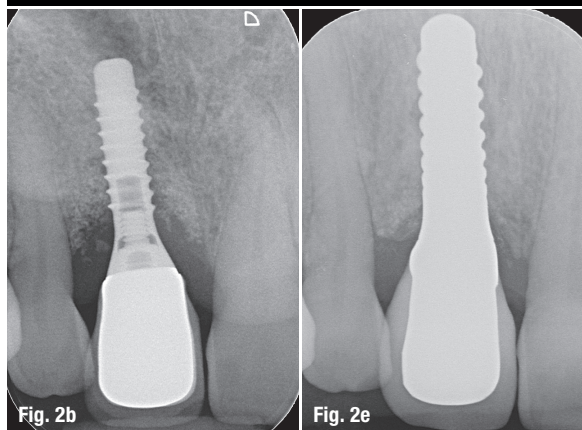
Initial clinical situation after non-surgical peri-implantitis pretreatment. Fig. 2b: Radiograph showing evident peri-implant bone loss. Fig. 2c: Clinical situation at implant placement (PURE Ceramic Implant Monotype, Straumann) four months after implant removal and subsequent augmentation with autogenous bone. Fig. 2d: Clinical situation four weeks after cementation of definitive crown. Fig. 2e: Radiographic control at delivery of definitive crown.
